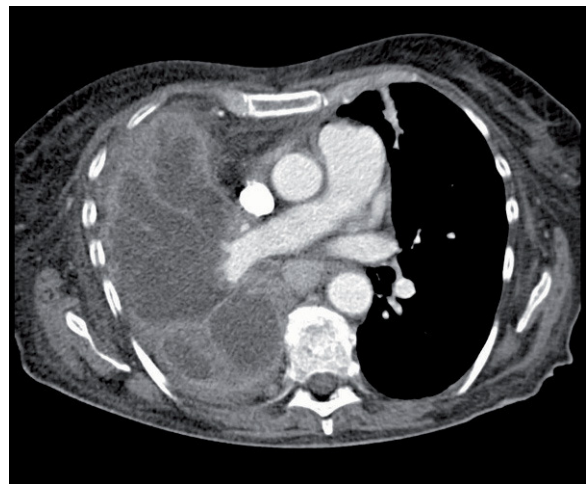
CT showing complete occupation of the RUL, persistent lymphadenopathies, mediastinal invasion and pleural effusion.
